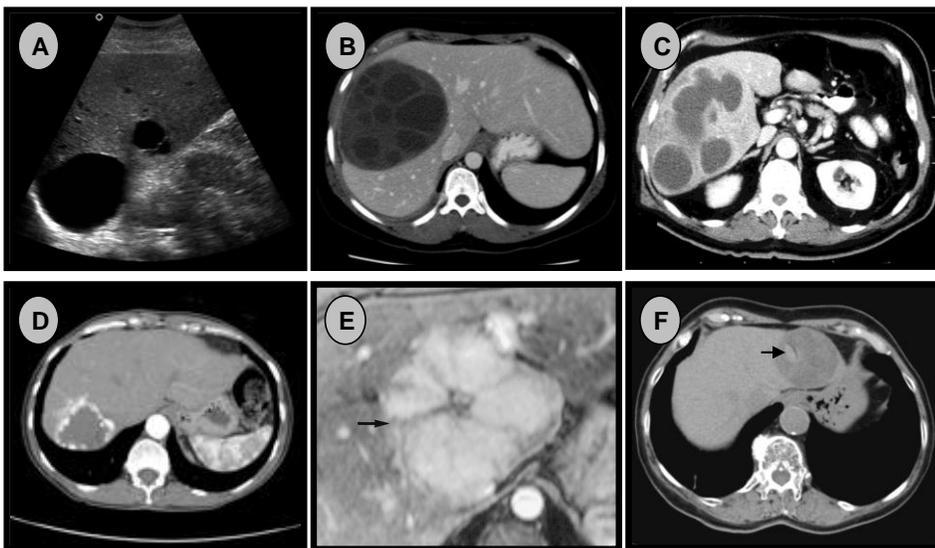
Radiographic findings of benign liver tumours. A) Simple cyst – hypoechoic on US with no internal septations or debris; B) Hydatid cyst – complex cystic mass on CT scan; C) Pyogenic liver abscess – note enhancement of the wall on CT scan; D) Hemangioma – CT scan demonstrates peripheral puddling of contrast; E) Focal Nodular Hyperplasia – MRI demonstrates the classic central scar (black arrow); F) Adenoma – CT scan demonstrates hyperenhancing area of recent hemorrhage (black arrow).
